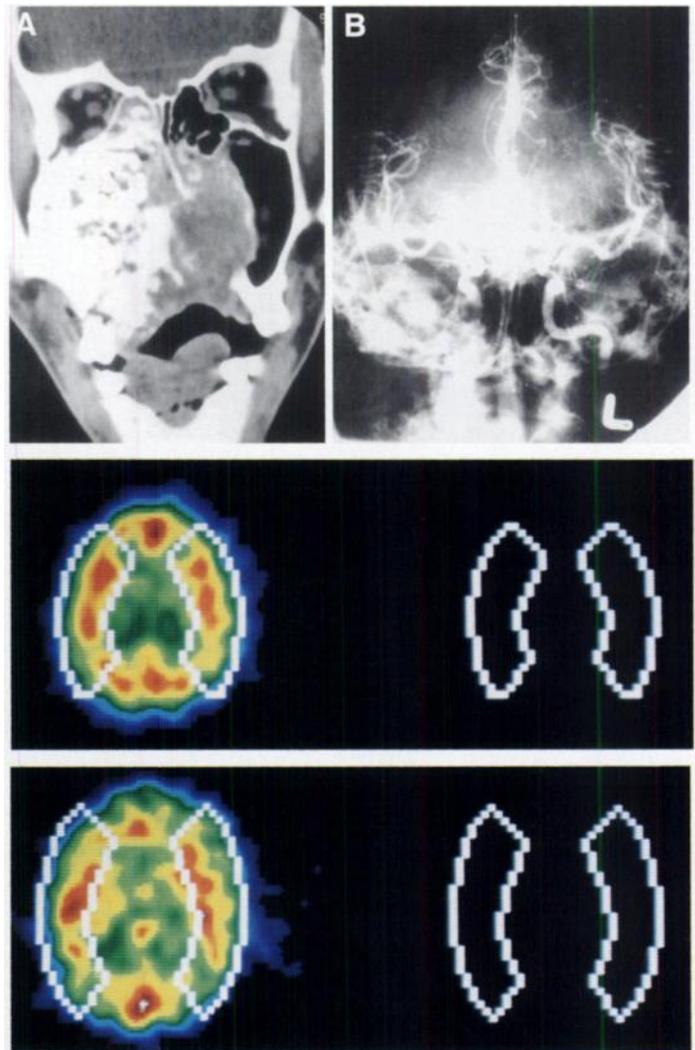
A 31-yr-old woman with pituitary adenoma. (A) Axial CT scan shows pituitary tumor encircling the left carotid artery. (B) Carotid angiogram on AP projection shows nonvisualization of the right middle cerebral artery during right carotid compression, probably from dysplastic change of right A1 portion. (C) Preocclusion brain SPECT shows no significant difference of radioactivity on semiquantitative analysis. (D) Postocclusion brain SPECT shows markedly decreased perfusion deficits in the left cerebral hemisphere. Loss of consciousness developed during left internal carotid artery occlusion.
